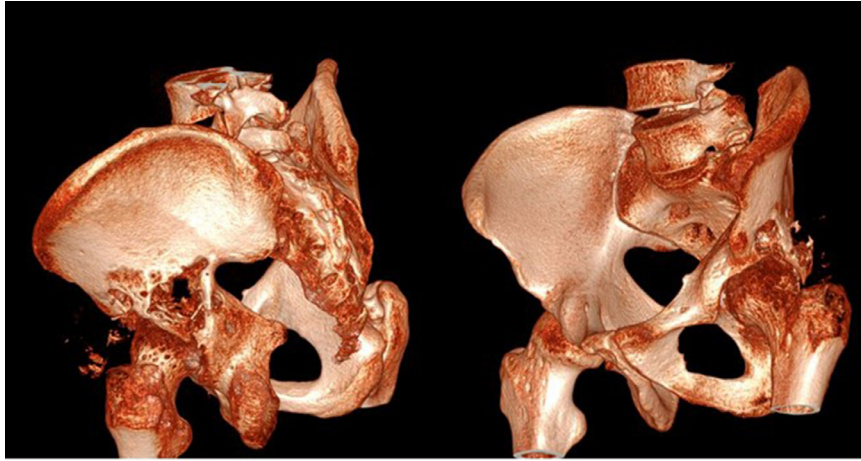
CT 3D reconstruction of lytic acetabular process.
